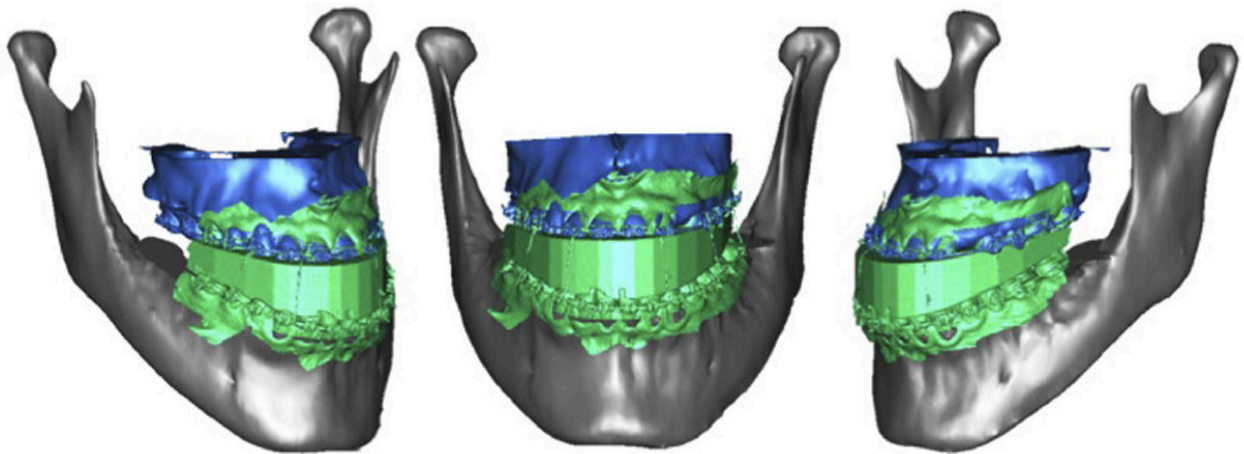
Alfaro's method of merging the ST dental scan with the CBCT dataset by means of best-fit algorithm.
